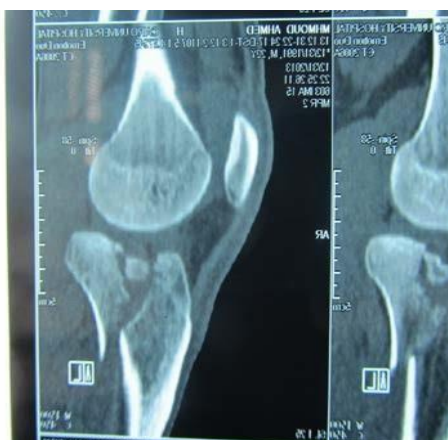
preoperative CT sagittal
